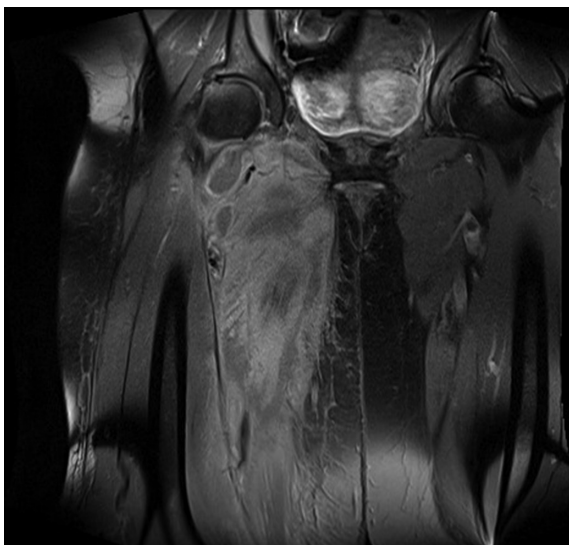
Coronal post gadolinium T1-weighted magnetic resonance imaging of the right thigh showing right adductor muscular swelling with loss of intramuscular fat strands, heterogeneous increased signal intensities, and rim enhancement when compared to the contralateral side. The signal intensity of the femoral bone is normal.
